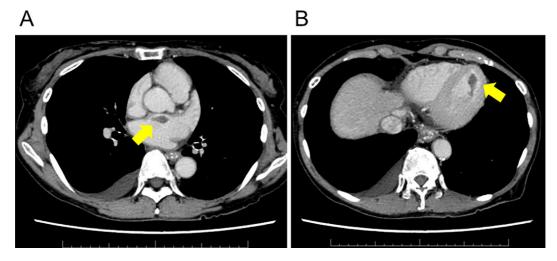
Contrast-enhanced computed tomography at admission showing left atrial thrombus (A, yellow arrow) and left ventricular apical thrombus (B, yellow arrow).
